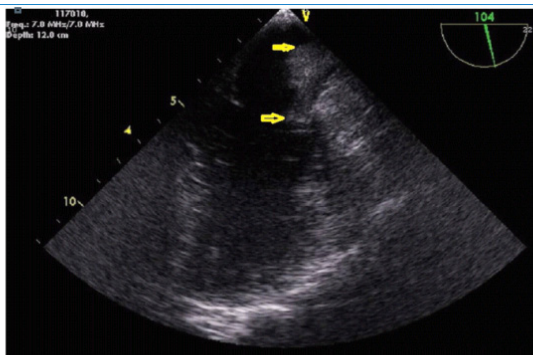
Transesophageal echocardiographic findings. A mass with irregular margin in the left atrium and unclear site of attachment (in midesophageal long-axis view showing) Laa left atrial appendicis ,LV left ventricle
